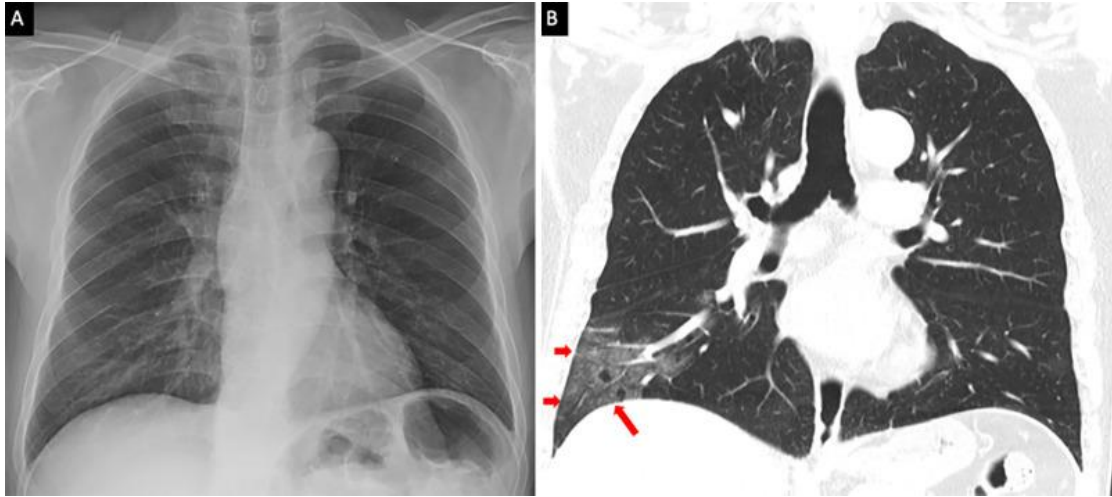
A comparison of, *A*, chest radiograph and, *B*, thorax CT coronal image. The ground-glass opacities in the right lower lobe periphery on the CT (red arrows) are not visible on the chest radiograph, which was taken within 1 hour of the CT.
